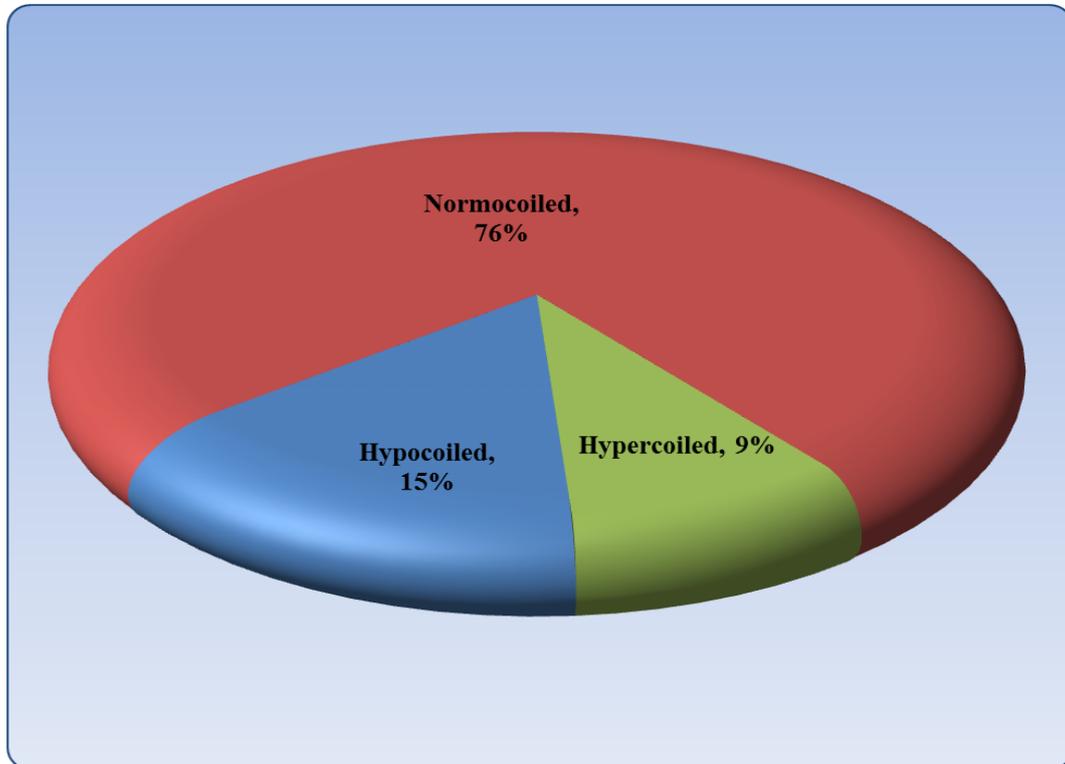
Distribution of the cases according to antenatal umbilical coiling index categories measured by ultrasonography, n=100.
